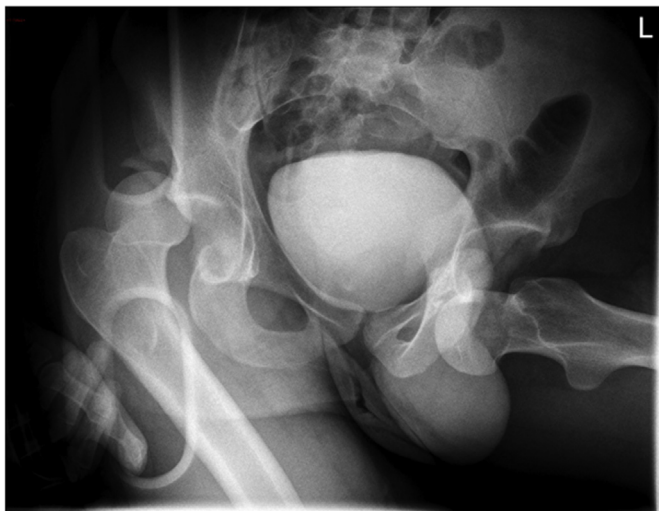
Pre-reduction x-ray.
